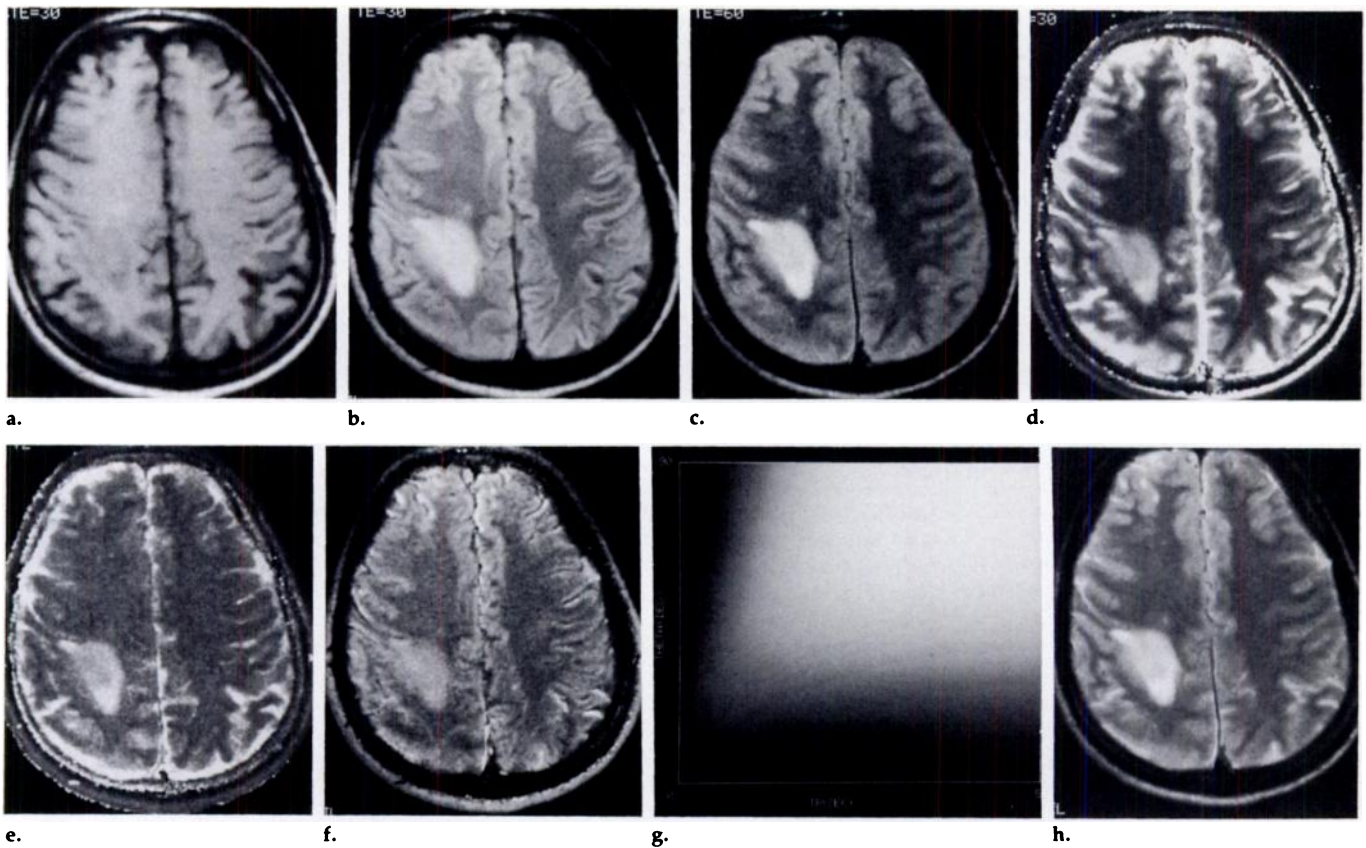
MR imaging sequence demonstrates process of predicting the behavior of partial flip angle imaging. (a) Spin-echo 500/30 image. (b) Spin-echo 2,000/30 image. (c) Spin-echo 2,000/60 image. (d) T1 image in which signal intensity is proportional to T1. (e) T2 image in which signal intensity is proportional to T2. (f) N(H) image in which signal intensity is proportional to N(H). (g) Partial flip contrast map of signal differences between the lesion (glioblastoma multiforme) and white matter at a TE of 60 msec. (h) Predicted partial flip image (500/60, θ 30°). A conventional contiguous multisection procedure consisting of a short TR image (a) and long TR, double-echo images (b, c) is used to generate T1, T2, and N(H) images (d, e, f). From these, a signal difference map (g) is generated for a TE of interest (in this case, 60 msec). The map shows the signal differences between the tumor and white matter as function of TR (horizontal axis) and θ (vertical axis). The largest signal difference is denoted by the highest intensities in the map. From the map, a TR, θ combination is chosen and used to generate a partial flip image (h) on a pixel-by-pixel basis based on the T1, T2, and N(H) values of the pixels.
